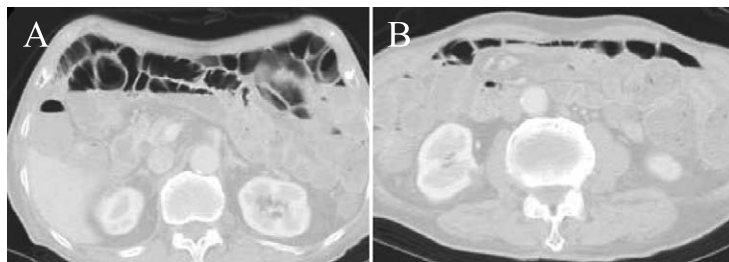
Abdominal CT on Day 7 of hospitalization
